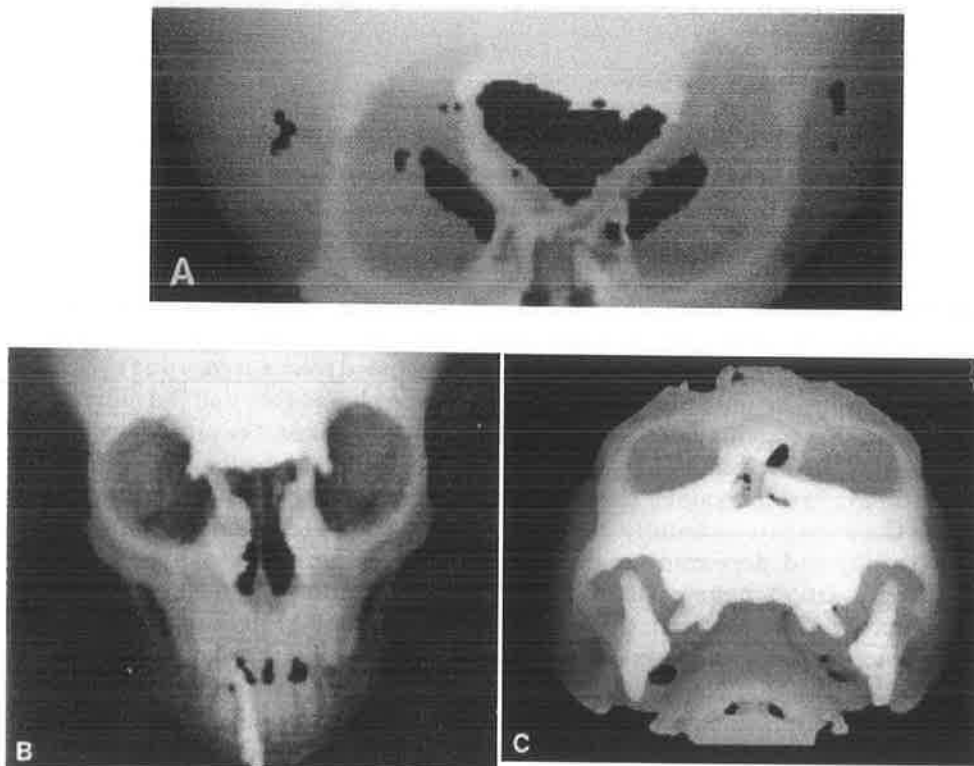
Three-dimensional computed tomography scan of facial defects associated with sincipital encephaloceles. A Naso-frontal type. B Naso-ethmoidal type. C Naso-orbital type.
